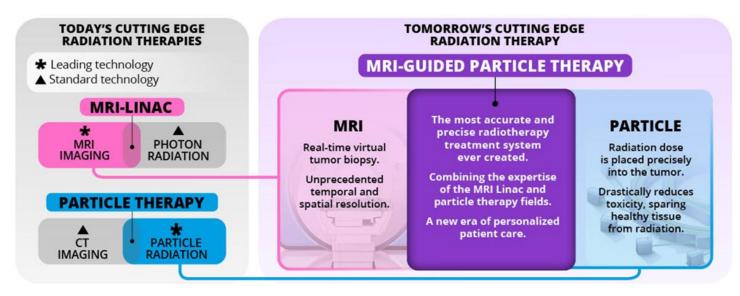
We plan to bring together the two most disruptive treatment devices in radiation therapy. We plan to design, build, and clinically pioneer MRI-Guided Proton Therapy.
